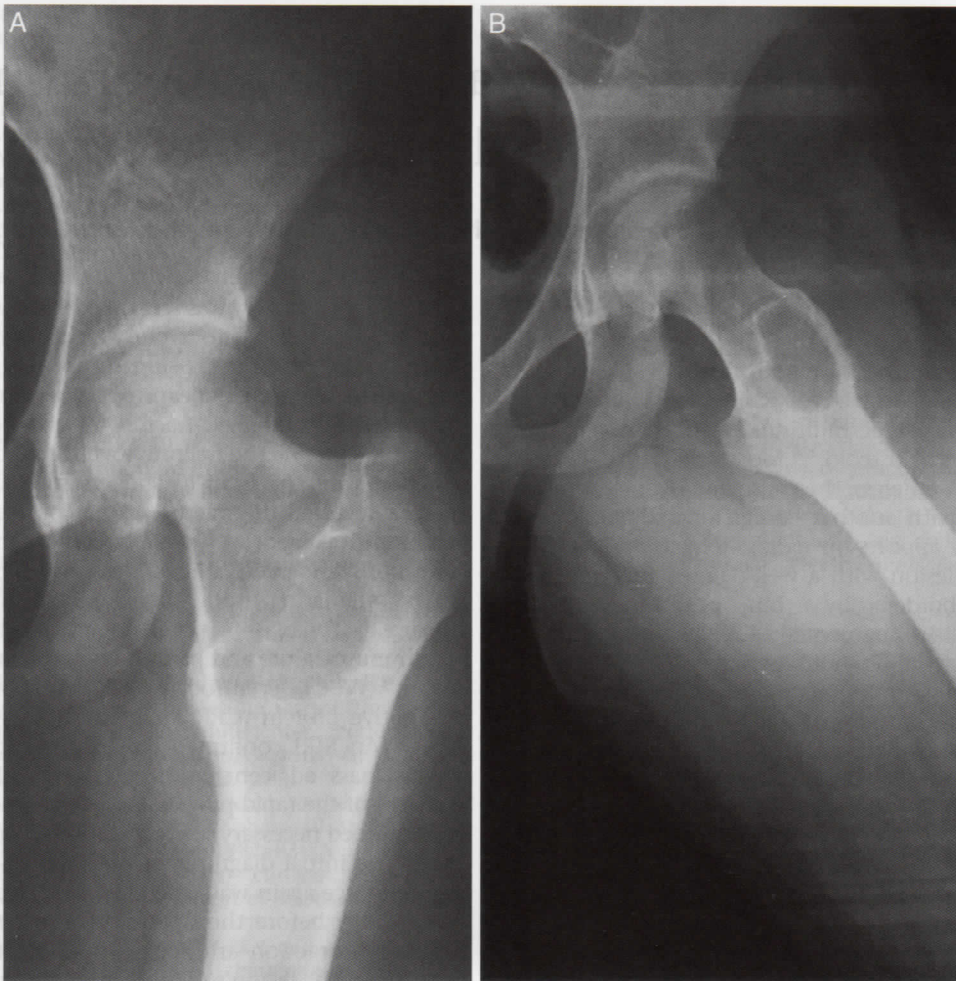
Anteroposterior (A) and lateral (B) radiographs of the affected hip depicting the typical eccentric, lytic and expansile characteristics of aneurysmal bone cyst.
